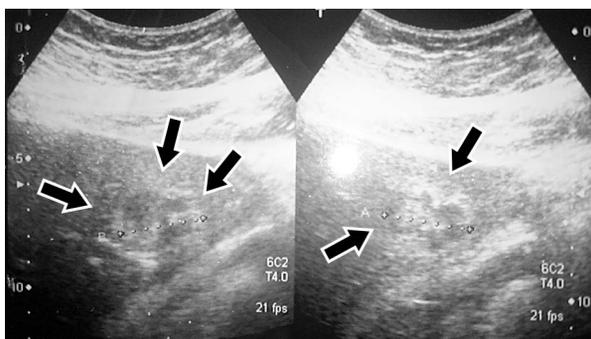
Ultrasonography: A focal oval hypo/hyperechoic lesion in the left hepatic lobe
